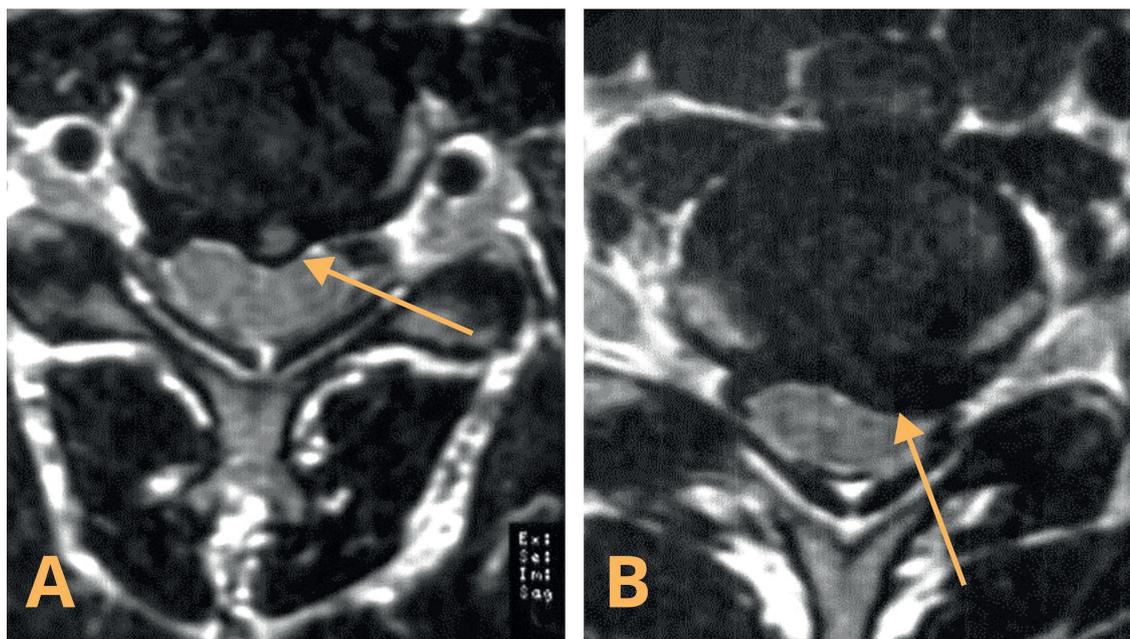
Cervical disc herniations. Axial T2-weighted magnetic resonance (MR) images of the cervical spine. A. In a patient with cervical spine pain; hyperintense (recent, "active") disc herniation with slight compression of the spinal cord (arrow); B. Another patient presenting with myelopathy and hypointense (chronic) disc herniation; marked compression of the spinal cord can be seen (arrow)
